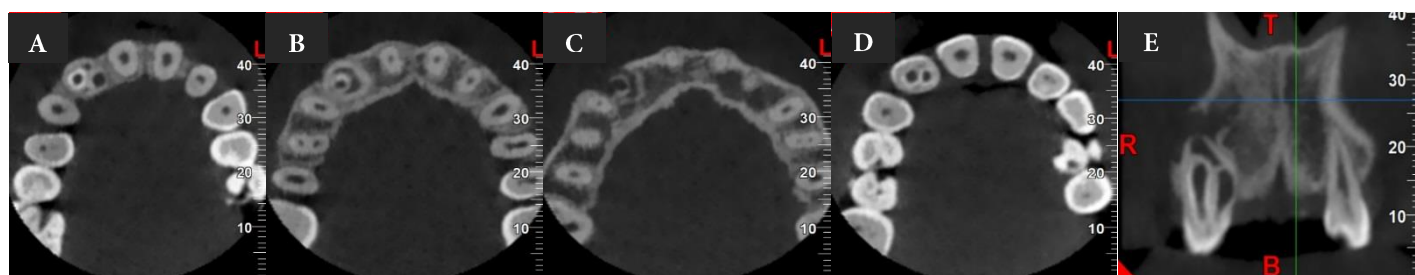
A) An axial view of the coronal third of the crown showing the 2 Dens Invaginatus canals surrounding with a complex root canal system; B) An axial view of the middle third of the crown showing the cul-de-sacs separated the canal into four portions; C & D) Axial views of the apical third of the crown showing the cul-de-sacs were protruded to apical part of canal but do not make any independent foramen; E) Coronal section of tooth #7, two cul-de-sacs were distinctly showed and periapical lesion was perforated the buccal cortex
